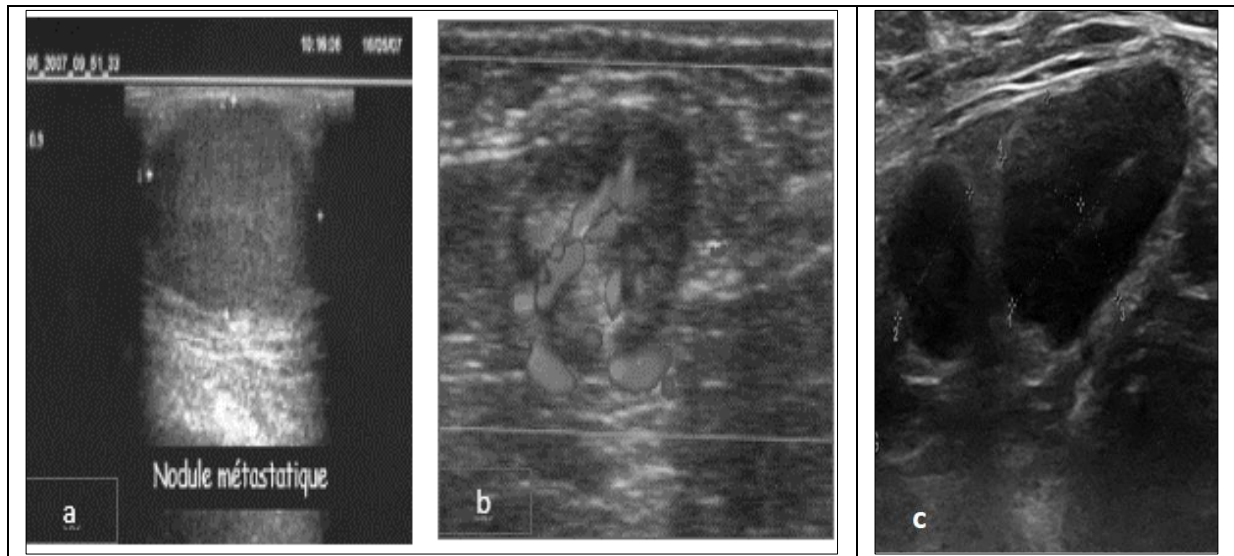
Ultrasound image
